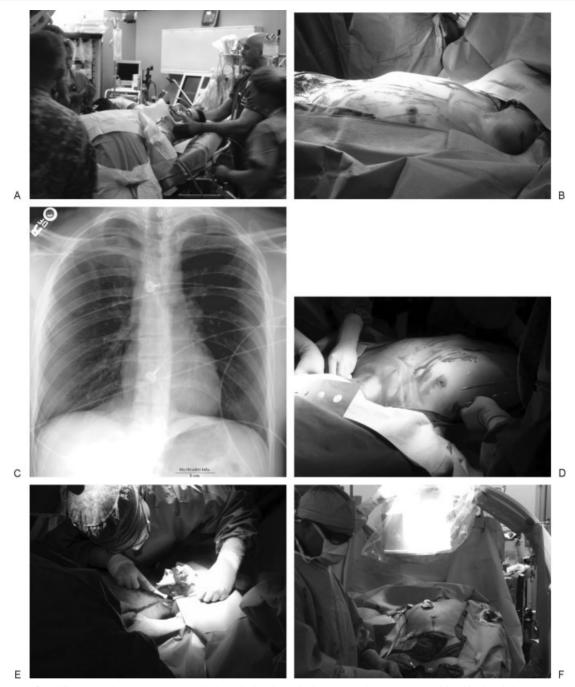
Providing care throughout the entire hospitalization. (A) A 24-year-old man was stabbed in the right upper quadrant, and in zone III of the left neck (above the angle of the mandible). Active bleeding from the neck was controlled with direct pressure. He was promptly transported to the operating room. (B) The interventional radiologist (IR) and trauma surgery attending discussed that it may be necessary to perform an arteriogram in the event of ongoing bleeding. In the operating room, the inguinal regions were prepped along with the abdomen, chest, and neck. (C) The chest radiograph was initially interpreted as normal, but the IR who was present in the trauma room was able to assist by identifying a right pneumothorax. (D) A right chest tube was placed at the start of the procedure. (E) Brisk bleeding was encountered when the neck wound was explored. (F) A cervical arteriogram was immediately performed using the right groin.
